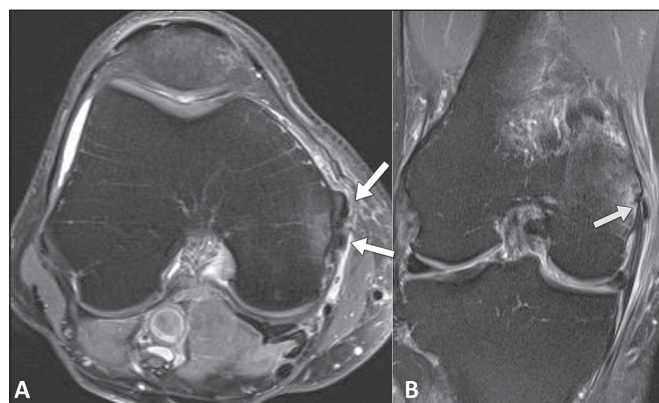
A 44-year-old male patient with a two-day history of pain in the medial aspect of the knee and a history of contusion due to a fall from standing height 20 days prior. A: Axial T2-weighted image with fat saturation, showing foci with low signal intensity (arrows), together with edema in the adjacent soft tissues and a pattern of bone edema in the medial femoral condyle. B: Coronal T2-weighted image with fat saturation, showing a small focus with low signal intensity, related to intraosseous calcific migration, with a pattern of bone edema, in the femoral condyle (arrow).
